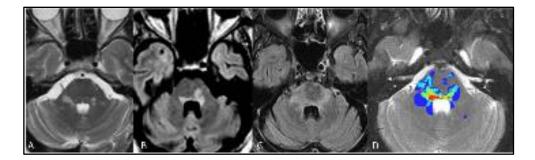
MRI Topography demyelinating lesions of the brainstem.
